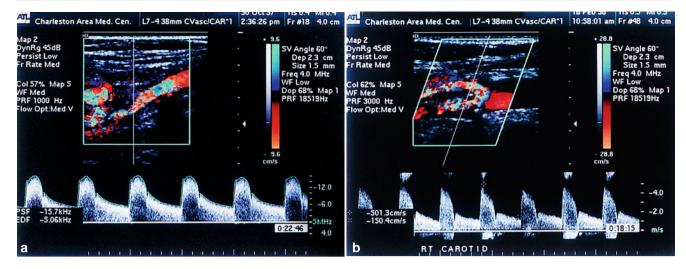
(a) A color duplex ultrasound image of the internal carotid artery showing Doppler spectra of tight stenosis (80–99%). The peak systolic frequency was 15.7 kHz with an end-diastolic frequency of 5.06 kHz. (b) A color duplex ultrasound image of an internal carotid
